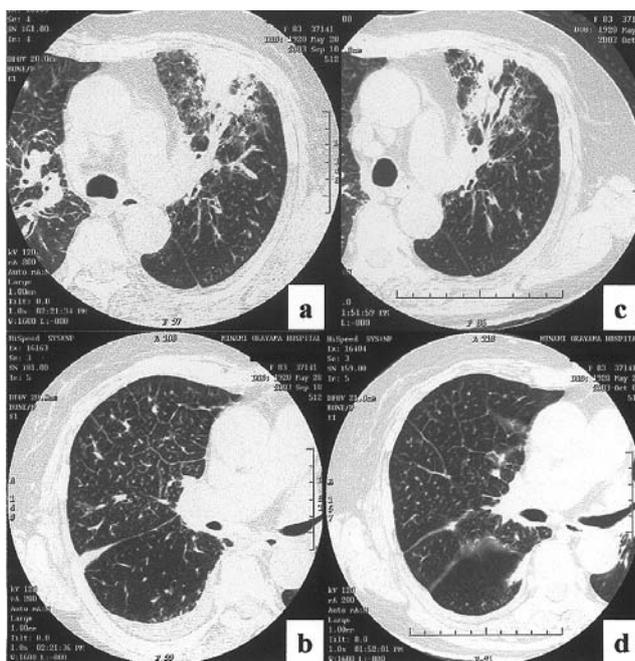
Chest CT films showing patchy consolidation on left S³b, thickening of the peribronchovascular interstitium surrounding vessels and bronchi, and peribronchial cuffing and interlobular septal thickening in the peripheral lung lesions (a, b: September 10, 2003); decrease of primary lesion and improvement of peribronchovascular interstitial and interlobular septal thickening (c, d: October 1, 2003).
